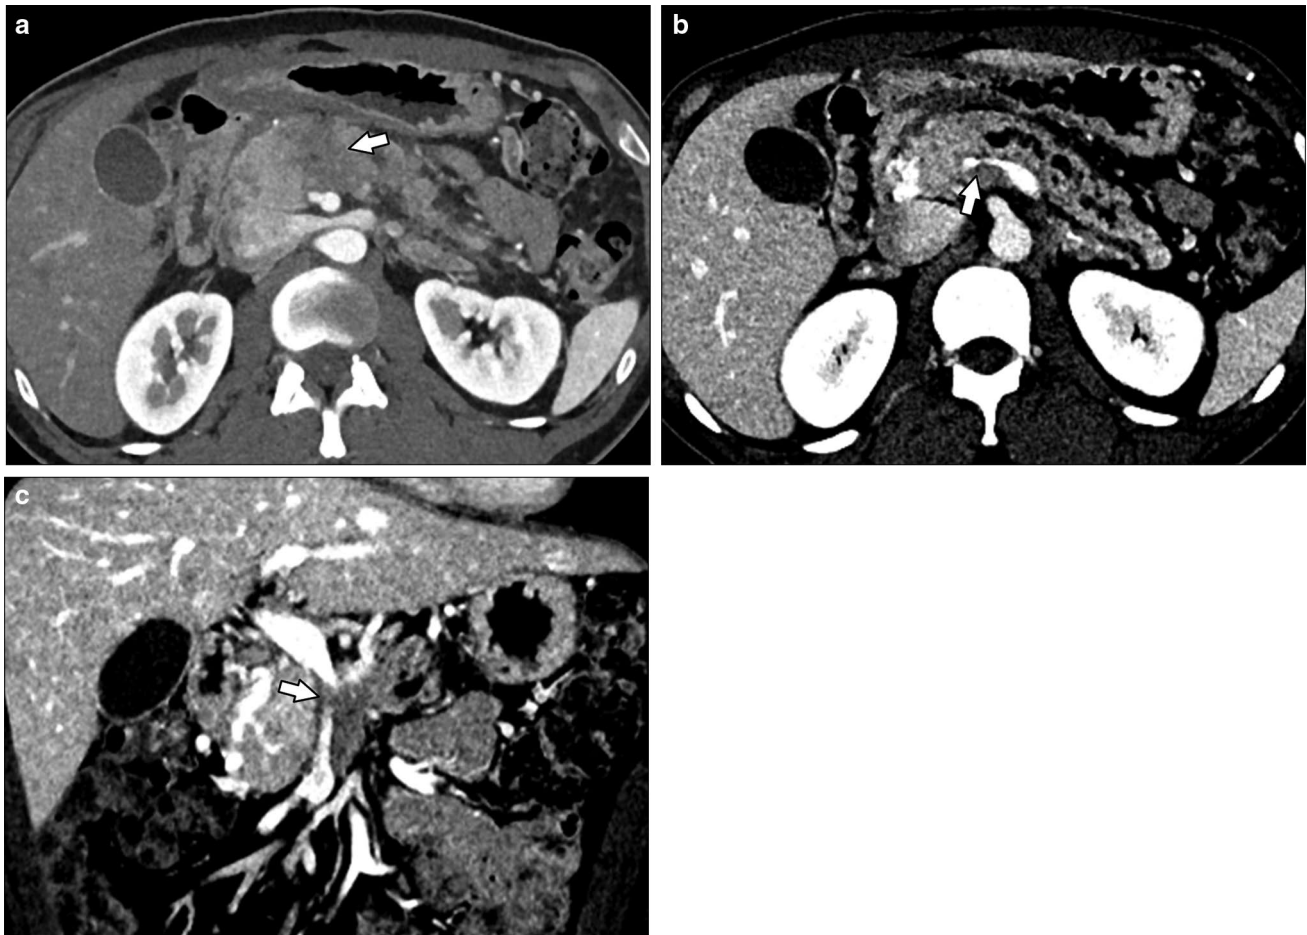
A 43-year-old male with pancreatic mass. a Axial contrast-enhanced arterial phase CT image shows a hypo-enhancing pancreatic neck mass (arrow) abutting the anterior aspect of the superior mesenteric artery. b Axial contrast-enhanced venous phase CT image shows
